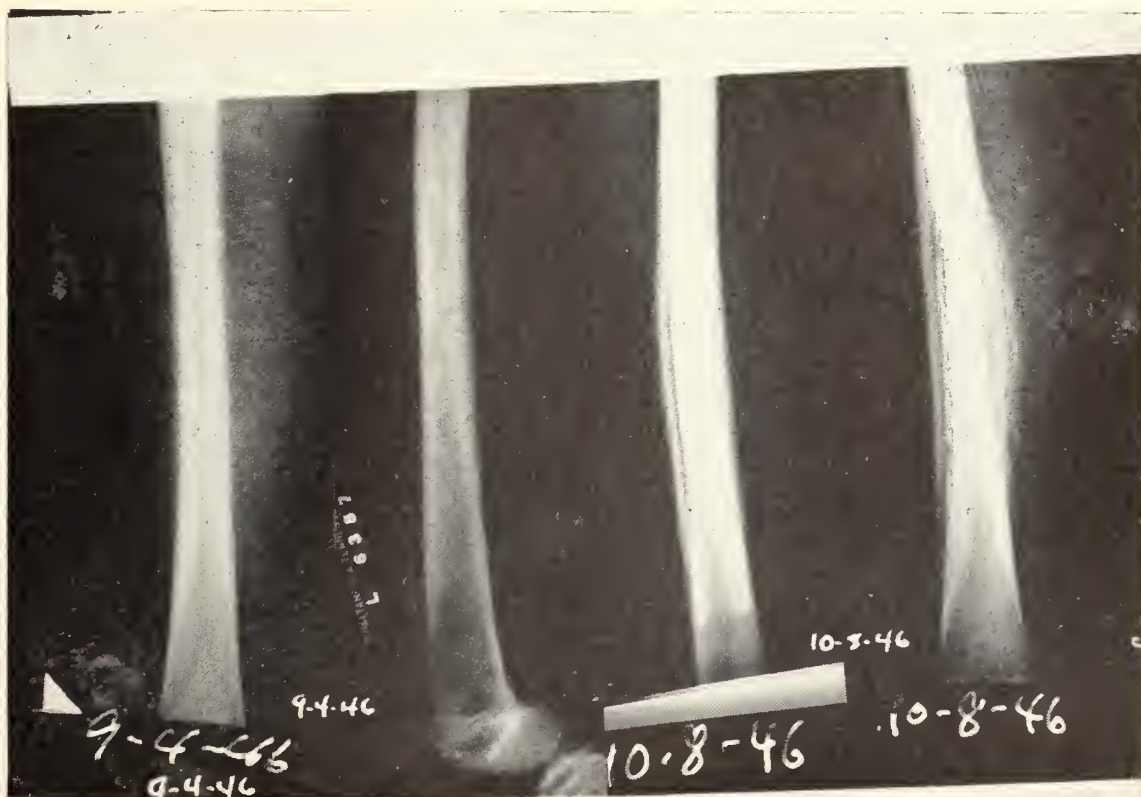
Case 3. Roentgenograms, September 4, 1946, and October 8, 1946. Nonoperative treatment of acute hematogenous osteomyelitis: Preliminary report. John J. Killefer, M.D., and Robert C. Robertson, M.D.
